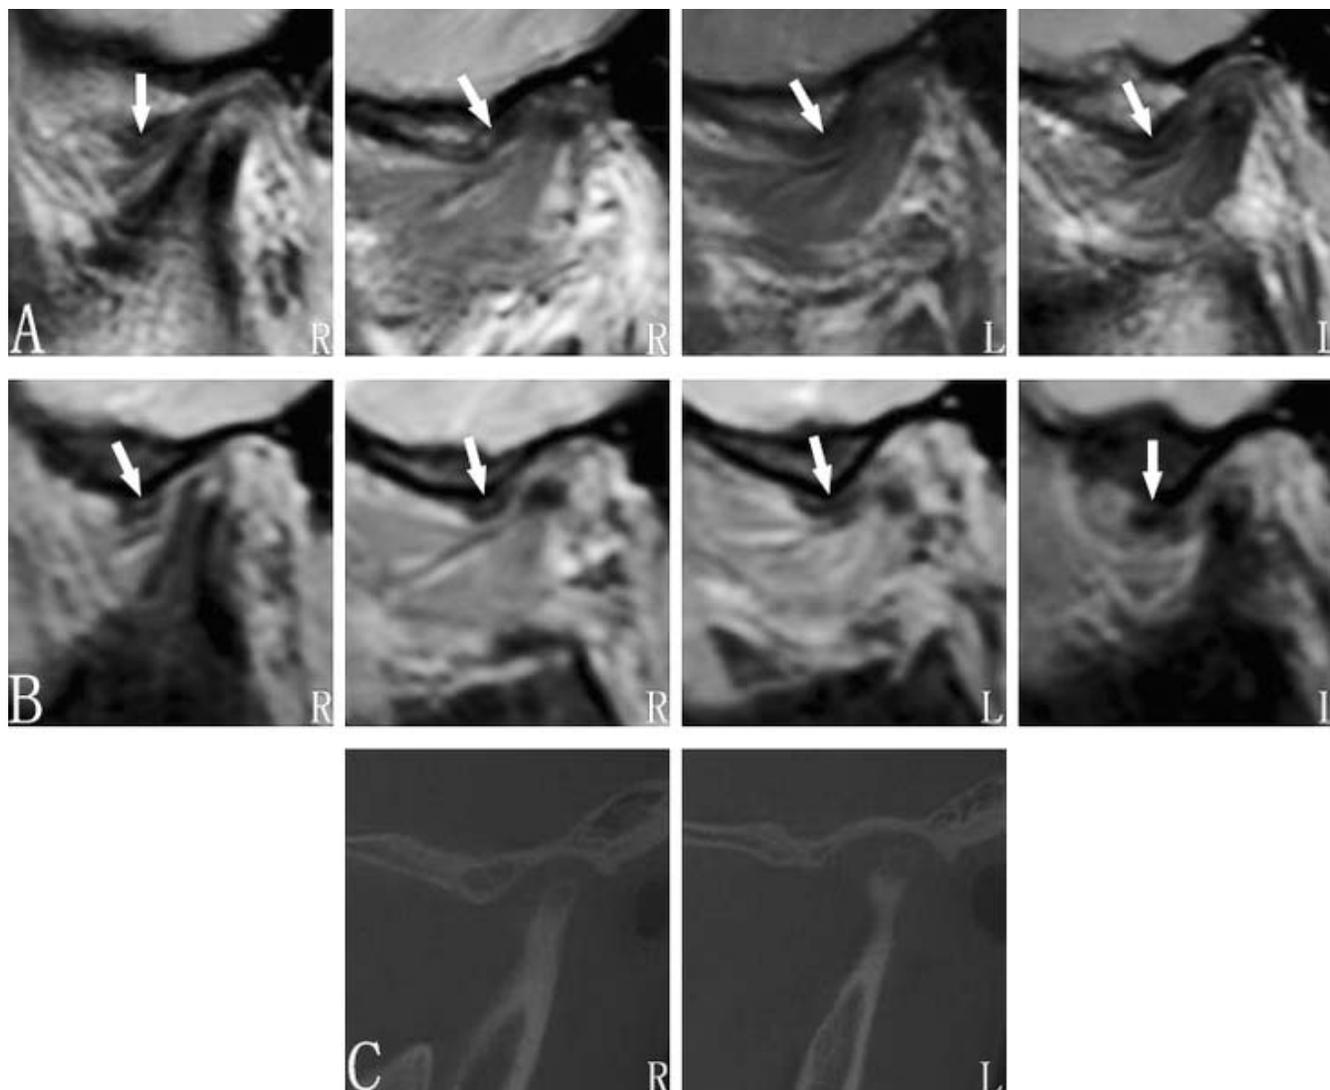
Pretreatment MRI (proton density-weighted images) and CBCT of TMJs: (A) disc (arrow) at both TMJs in oblique sagittal view of closed-mouth position on MRI; (B) disc (arrow) at both TMJs in oblique sagittal view of open-mouth position on MRI; (C) CBCT of both TMJs (R indicates the right TMJ; L, the left TMJ).
